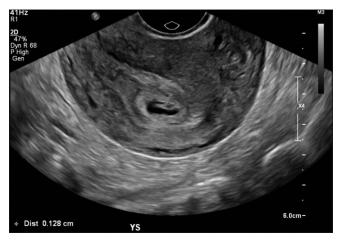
Sagittal view of the uterus on transvaginal sonography showing gestational sac corresponding to 5 weeks and 4 days of gestation and a 0.1-cm yolk sac
